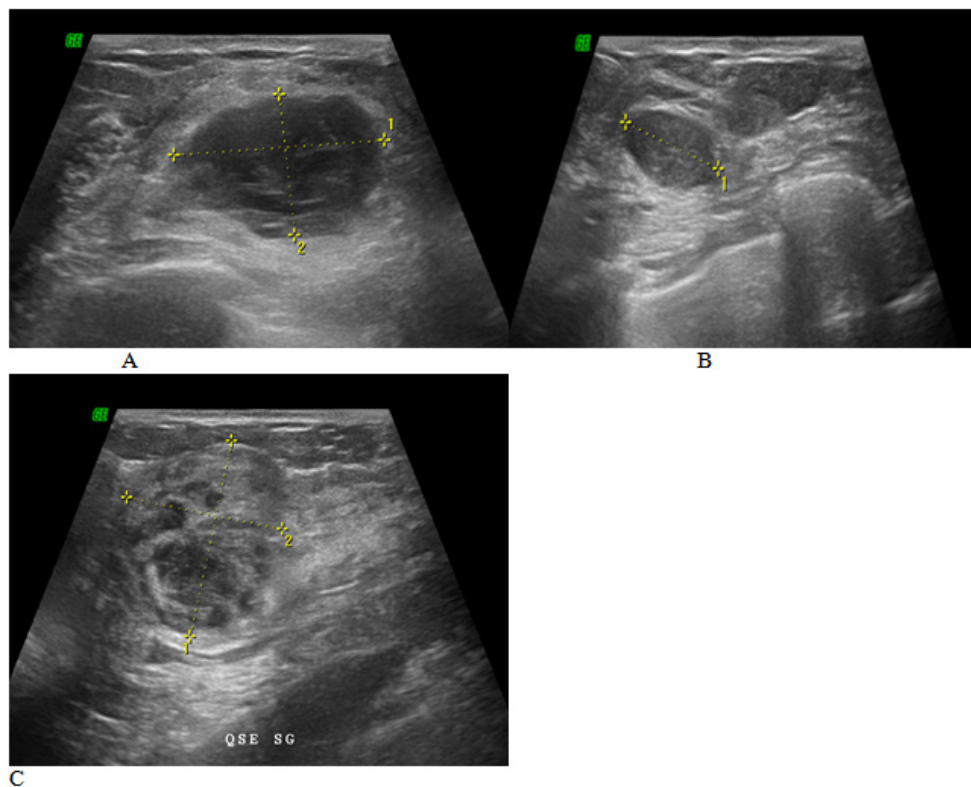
Ultrasound images.
